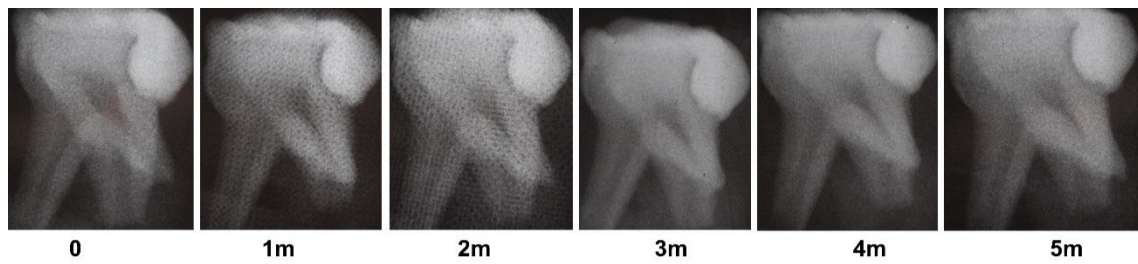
X-ray images sequence (up to 5 months) of a carious primary tooth that was restored atraumatically with F10 then immersed in AS and had SBF pumped through its pulp chamber.
